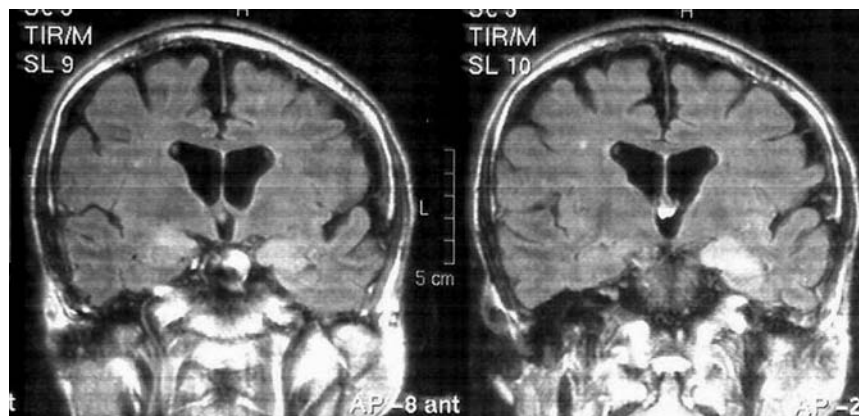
Coronal FLAIR sequences of brain MRI revealed increased signal on bilateral limbic areas: 153 × 73 mm (150 × 150 DPI).
